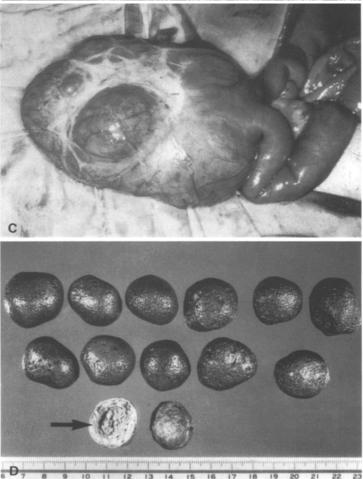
A CT of the pelvis shows a large cystic mass containing several enteroliths with peripheral calcification and central air density (*asterisks*), located within fluid mixed with gas bubbles (*arrows*). UB, urinary bladder; R, rectum.
